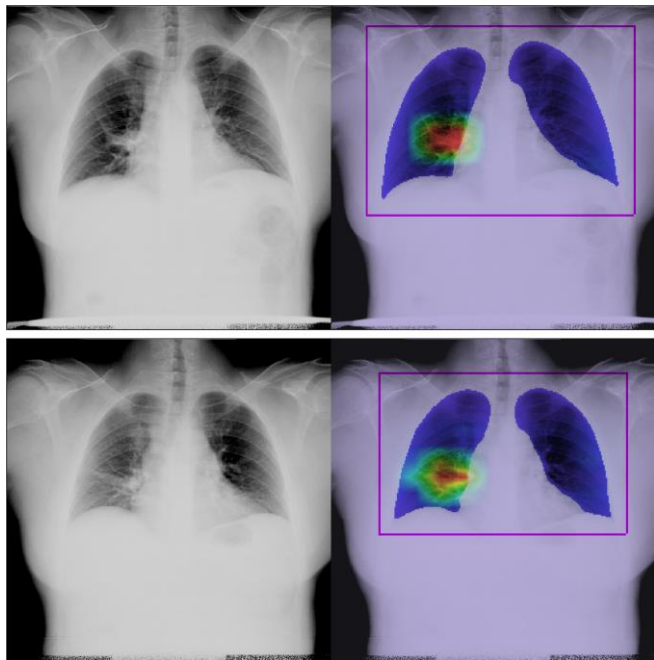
Two subsequent X-ray scans of a single patient with ~1 year difference; the first image was diagnosed as normal, whilst the second one is reported to have an abnormality in the right lung; automatic X-ray CAD correctly localized the abnormality in both cases
